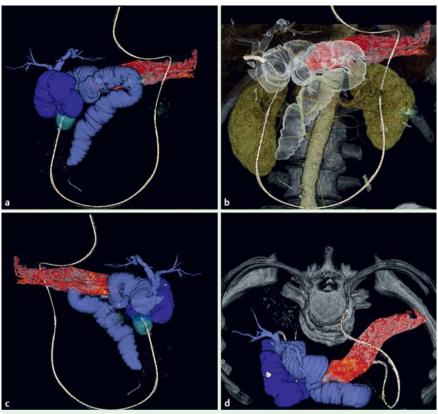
Stereoscopic images constructed using computed tomography (CT) enterography showing the relationship between the pancreaticojejunal anastomosis and the hepaticojejunostomy site in: a frontal view; b transparent version of the frontal view; c back view; d head view.
